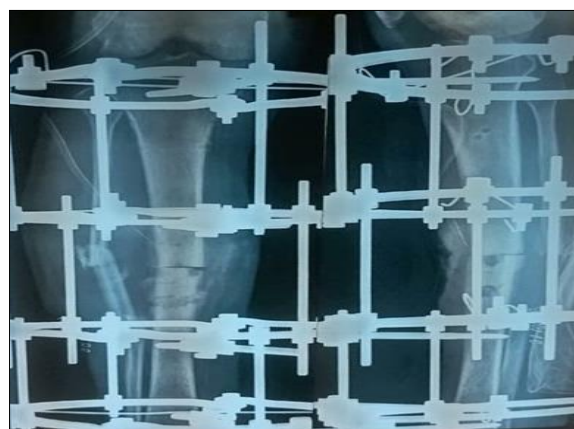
X-ray showing Non-Union Fracture Tibia and Fibula with Ilizarov fixator in-situ.
